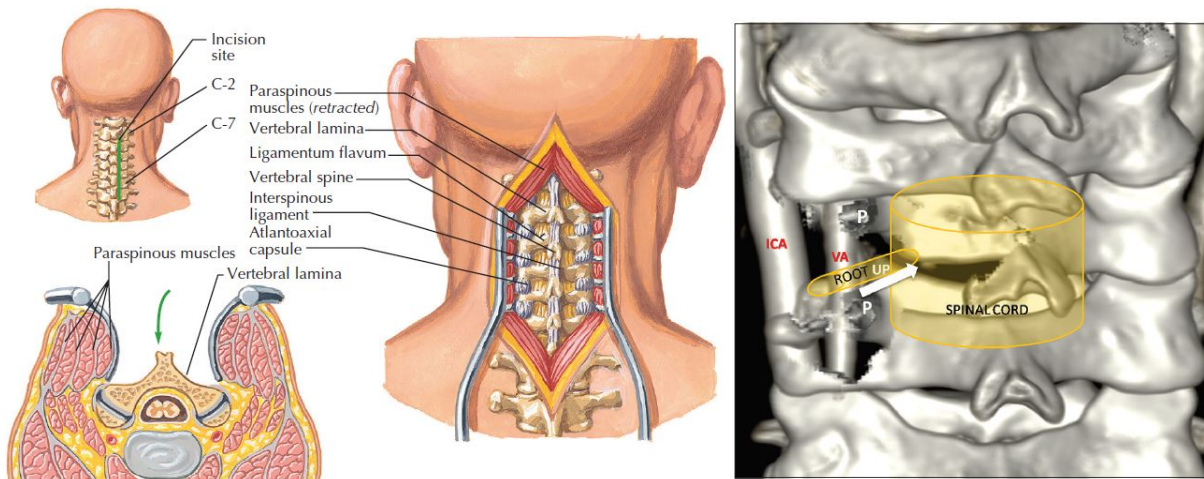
Posterior open approach to the cervical spine (left) [7]. Transforaminal approach for cervical interbody fusion with allograft (right) three-dimensional surface reconstruction of cervical computed tomography scan image with angiography where the lamina and lateral mass are digitally subtracted and the encountered nervous structure (spinal cord and root) are highlighted [35]. The UP arrow shows the used trajectory to the intervertebral disc space. ICA: Internal carotid artery, VA: Vertebral artery, P: Pedicle in cross-section, UP: Uncinate process.
